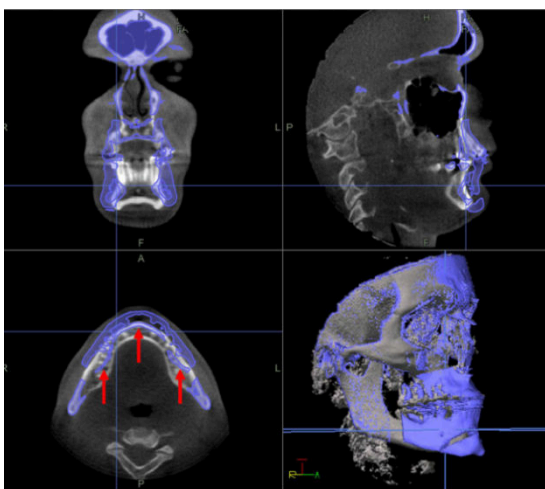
Superimposition of the pre cbct images and .Stl file of the virtual plan, as reported by Mazzoni et al.
